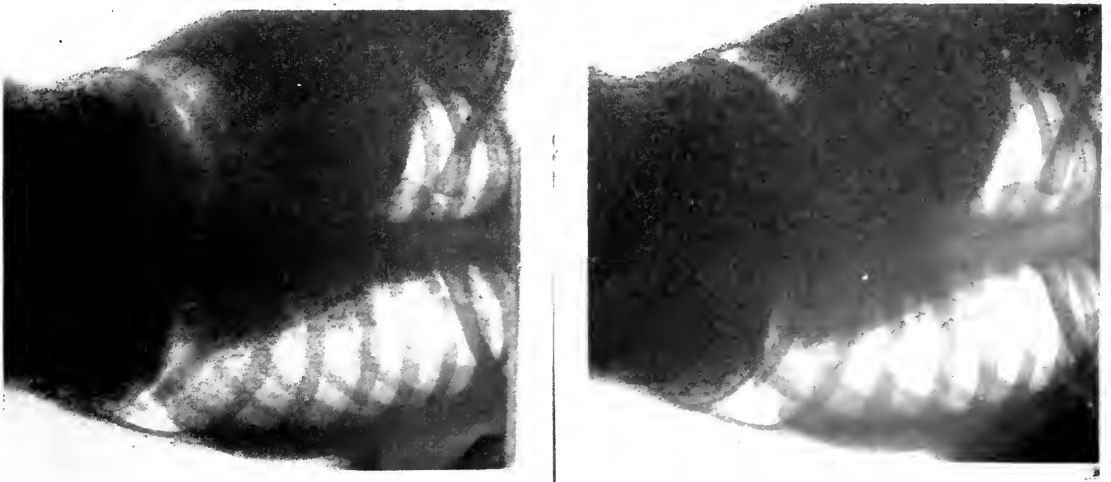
These plates were taken eight weeks later or about fifteen months after the first roentgen-ray findings (Fig. 1).
